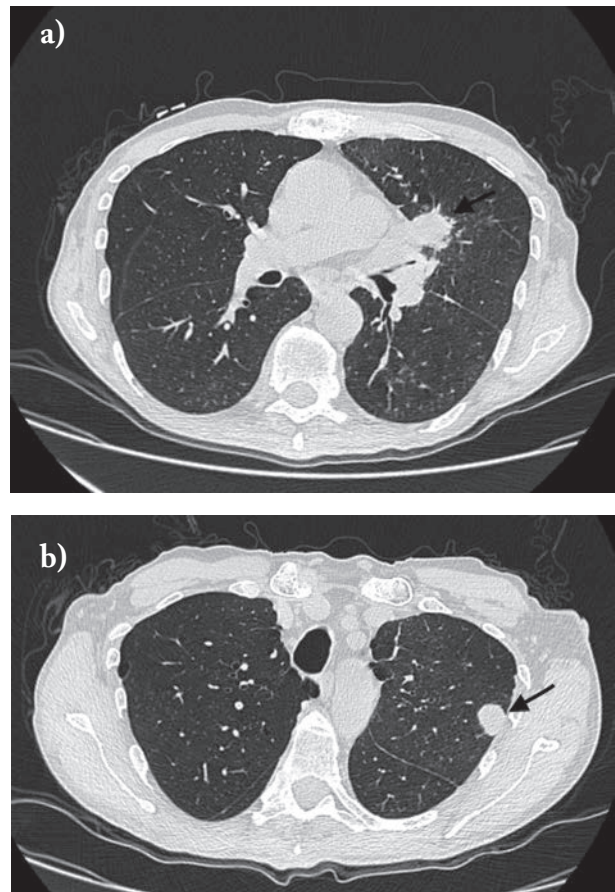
Computed tomography revealed a solid expansive process in the upper lobe of the left lung.
